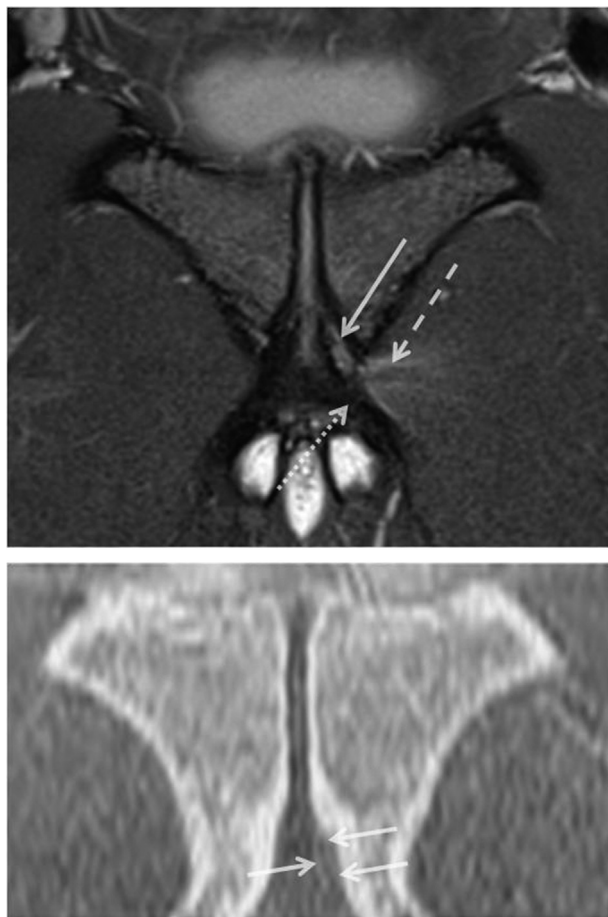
A 30-year-old elite AFL player with left groin pain. Coronal T2-weighted fat-saturated MRI (top image) showing left inferior pubic apophysitis. Intermediate to high T2 signal is seen at the left inferior pubic apophysis associated with the gracilis-adductor brevis attachment (arrow), in continuity with the symphyseal disc. There is mild tendinosis of the gracilis tendon (dotted arrow), with increased signal compared to the right, and oedema at the adductor brevis pubic attachment (dashed arrows). Coronal oblique inverted VIBE MRI at the same level (lower image) demonstrates delayed ossification of the left pubic apophysis and subtly increased apophysis signal (between arrows) relative to symphyseal cartilage, compatible with apophysitis. Noted the thin secondary ossification centre (left arrow), corresponding to a Stage 2 apophysitis.
